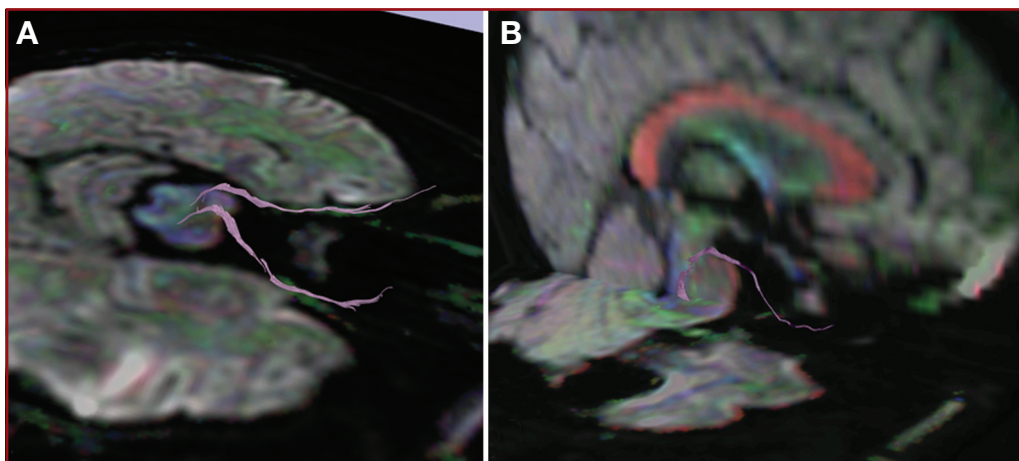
Intra- and extracranial course of cranial nerve III, depicted onto mixed anatomic/color-by-orientation MRI slices. Images are overlaid onto axial MRI slices (A) and sagittal MRI slices (B). The intracranial course takes a sharp angle, after which the fibers appear to enter the medial longitudinal fasciculus. The large commissural fibers of the corpus callosum (red) and fornix (blue) can be easily visualized on the sagittal slices. (Please see also Supplementary Digital Content 2, Figure 2, a 3-dimensional representation of the oculomotor nerves.)
